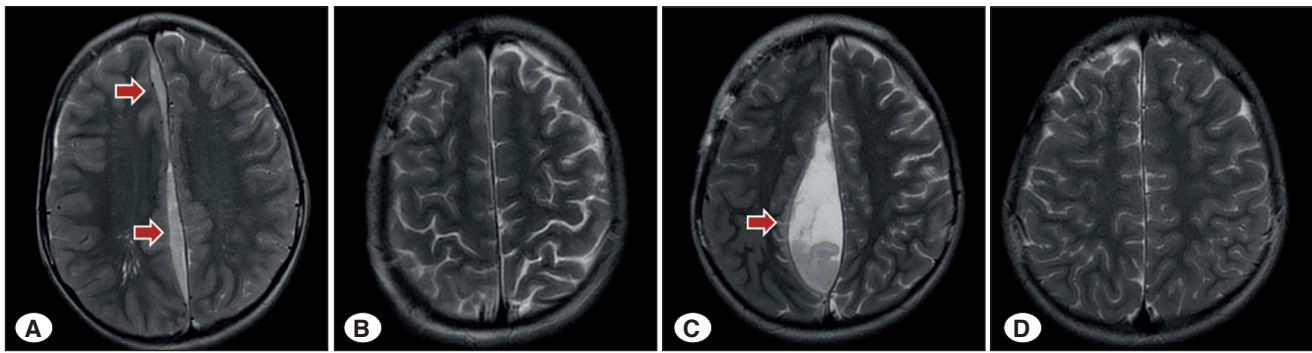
A 7-year-old boy with interhemispheric subdural empyema who required a second surgery due to early residual empyema progression. A) Axial T2-weighted magnetic resonance imaging (MRI) demonstrates a diffuse right-sided interhemispheric subdural empyema (red arrows). B) Early postoperative axial T2 MRI after initial surgical drainage shows effective evacuation of the empyema; however, the right cortical hemisphere remains markedly edematous. C) Axial T2 MRI obtained on postoperative day 6 following the development of acute right central facial palsy reveals progression of the subdural empyema in the posterior interhemispheric region (red arrow), prompting urgent reoperation; the facial palsy completely resolved by postoperative day 2 after the second surgery. D) Follow-up axial T2 MRI at 3 months after completion of 10 weeks of antibiotic therapy demonstrates complete resolution of the empyema without residual collection.
